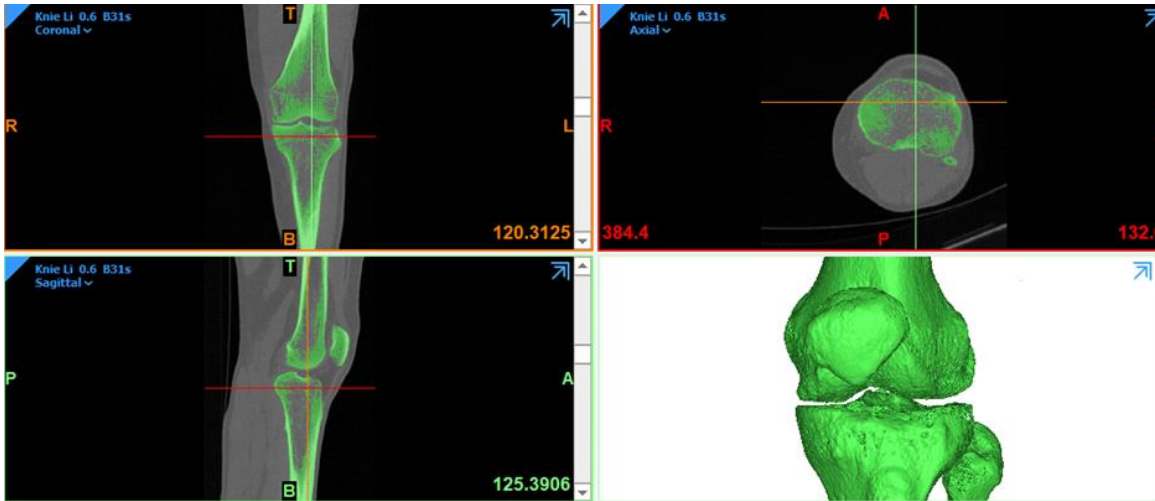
CT-scan segmentation and 3D modelling of the index knee in Mimics 23.0
